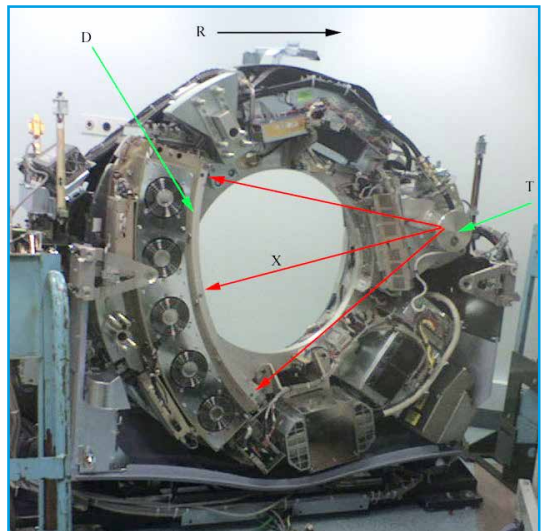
CT scanner with cover removed to show internal components. Legend: T: X-ray tube, D: X-ray detectors, X: X-ray beam, R: Gantry rotation. https://en.wikipedia.org/w/index.php?title=CT_scan&oldid=931133973 (accessed 30 December 2019).
